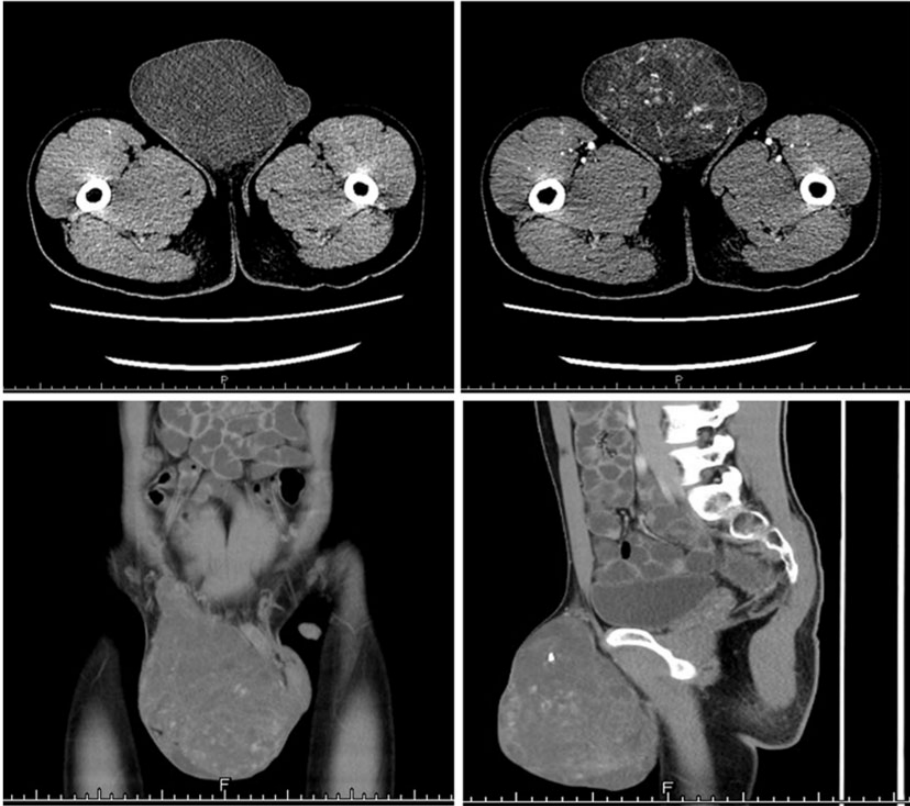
Computed tomography of a 22-year-old man with a giant scrotal mass. Preoperative computed tomography of the abdomen demonstrates a giant ($14.5 \times 12.0 \times 9.5$ cm) solid mass in the right side of the scrotum without necrosis. Heterogeneous enhancement is seen during the arterial phase, and large amounts of tortuous vessels were observed.
